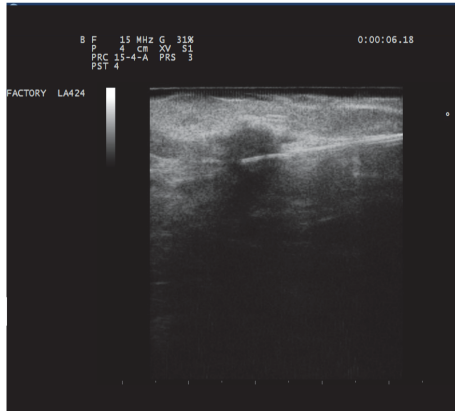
The device LA (introducer-needle and fiber) must be progressively inserted towards the target, choosing the best path to correctly position the tip of the fiber. It is necessary to ensure that the path of the applicator is as parallel as possible to the chest wall. The tip of the device should always be inserted at the center of the lesion and its position must always be controlled with two-plane ultrasound images.
